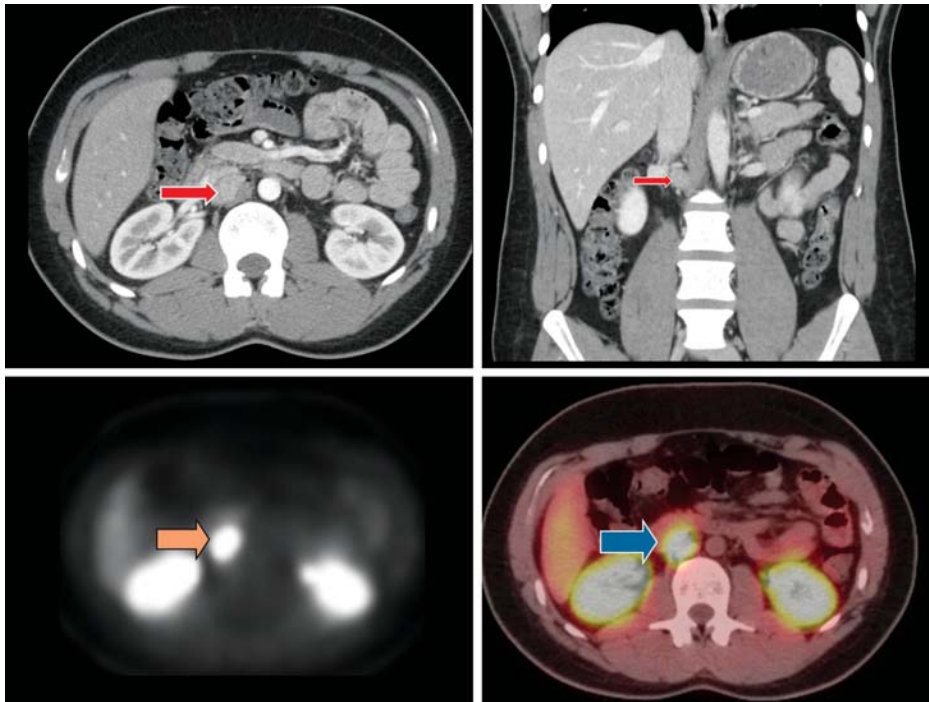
Abdominal CT (at the top) and 18F Dopa-PET (bottom) showing a 27 mm paraganglioma located behind the vena cava at the level of confluence of renal veins
